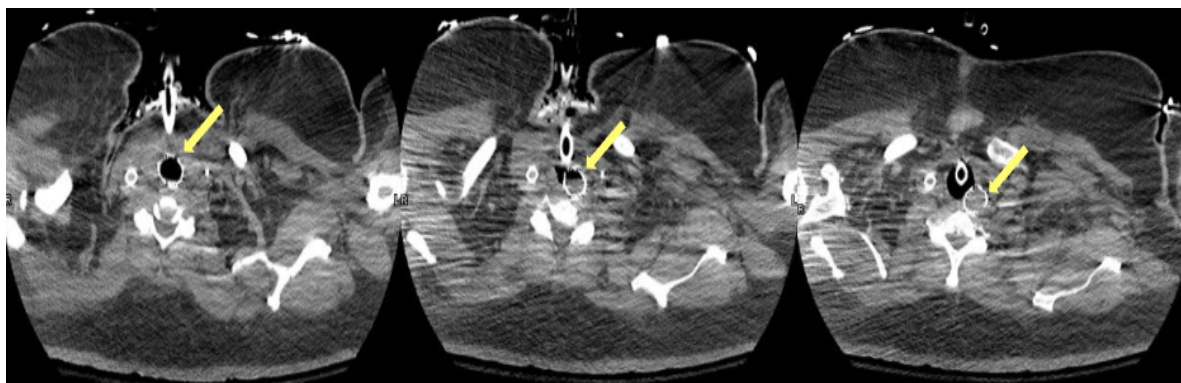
CT scan showing migration of the tracheal stent into the esophagus.
